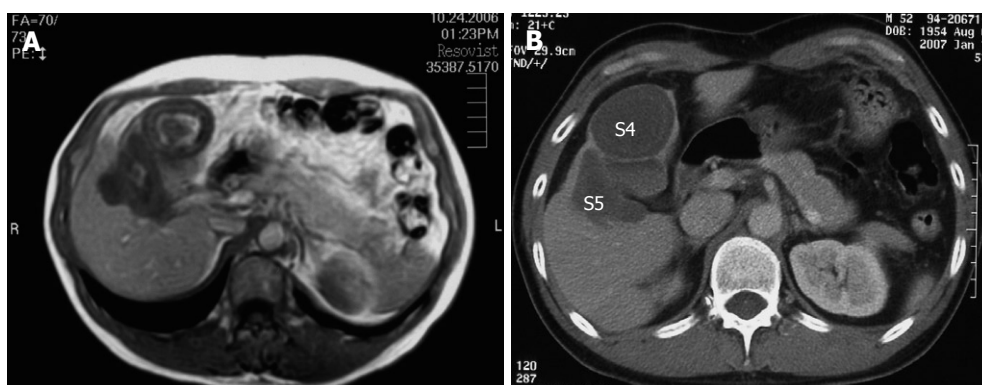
MRI on T1-WI 30 mo after treatment with Imatinib (A) and contrast-enhanced CT 34 mo after the treatment with Imatinib (B). The metastatic lesions (S4 + S5) are indicated.
